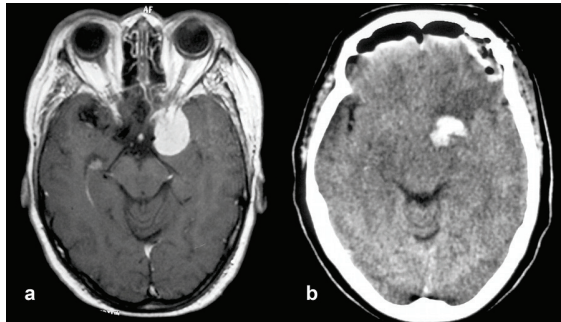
a.: Preoperative post gadolinium MRI T1w axial showing a meningioma of the left anterior clinoid, b. Post-operative CT scan showing hemorrhage at the resection site
